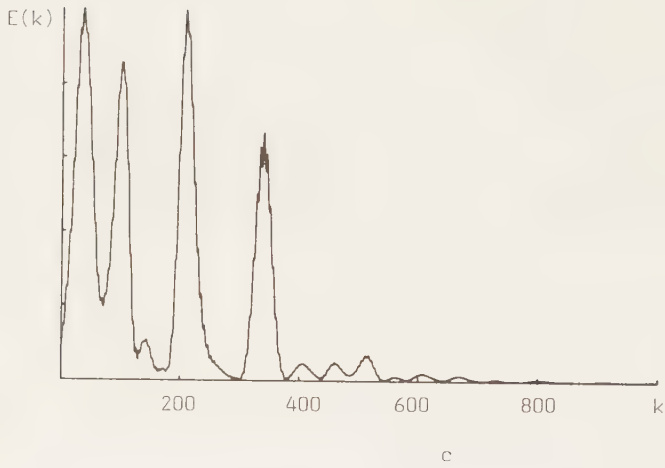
Short-time energy $E(k)$ of the ultrasonic signal (Fig. 1.6c) and $\ln(1/E(k))$ with a straight mean-squares line (Fig. 1.6d) for a narrowband transducer.
